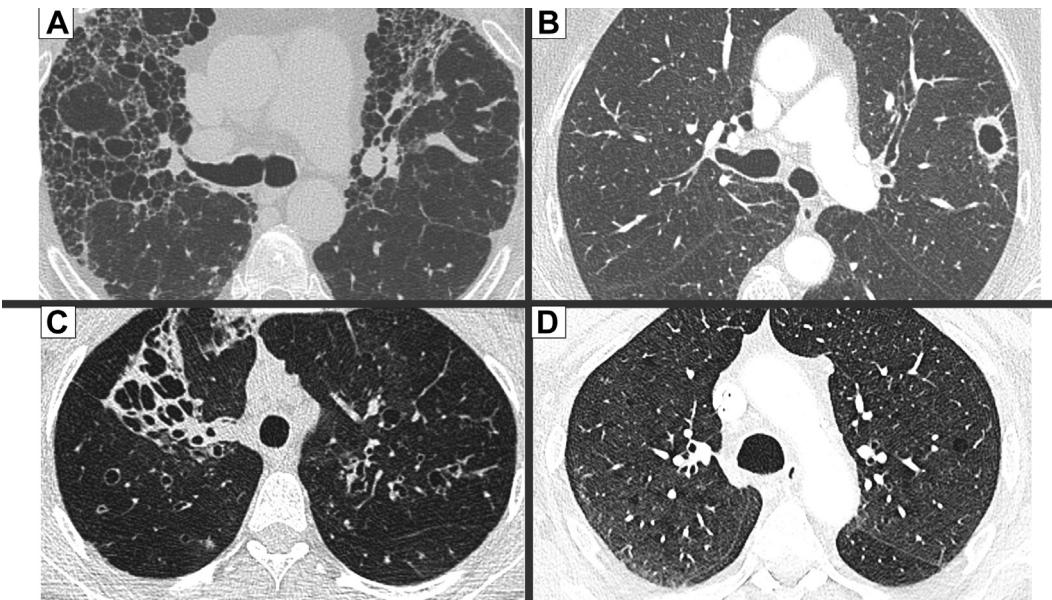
A-D, Common mimics of cystic lung disease identified on CT scan. (A) Honeycombing typical of pulmonary fibrosis. (B) Lung cavity/abscess, demonstrating a thick, well-described wall, not typical of a cyst. (C) Cystic bronchiectasis, best appreciated by identifying continuity of the airway on contiguous CT slices. (D) Subtle centrilobular emphysema, usually differentiated by the absence of a definite cyst wall, and the presence of vessels running through the airspace.
